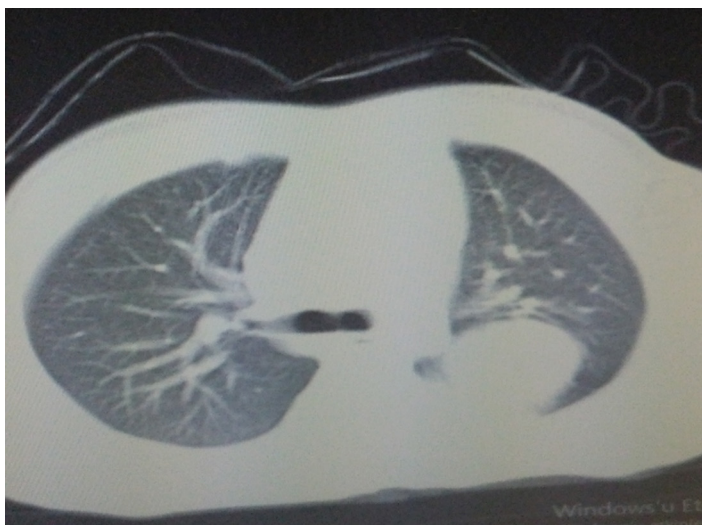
CT imaging of hydatid cyst located in the left lung
